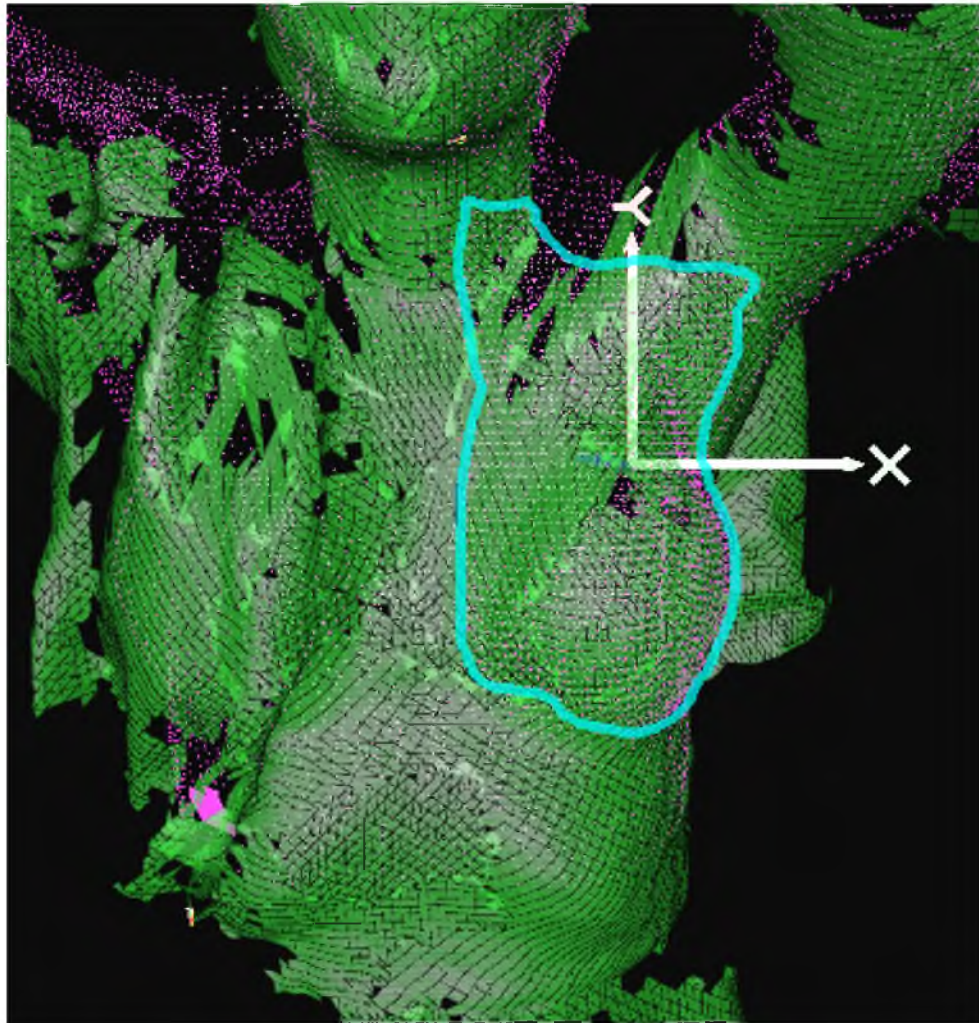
PMRT patient setup at the time of treatment using surface imaging; the finely dotted pink mesh represents the skin contour based on the planning CT while the green area represents a daily setup image that was evaluated for setup registration. The patient could therefore be accurately setup based on the shallow target, virtually represented by the cyan contour, using the skin surface rather than bony anatomy.
